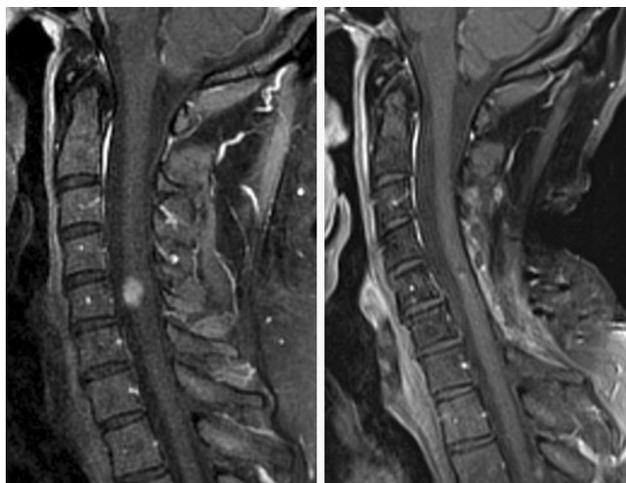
Sagittal cervical T1 post-contrast MR images of our second patient (40-year-old male, C4-5 lesion) from Table 1. Preoperative image (*left*) shows characteristic cord expansion and hyperintense tumor with evidence of hemorrhage, necrosis, or calcification. Postoperative image at 2 year followup (*right*) confirms gross total resection
